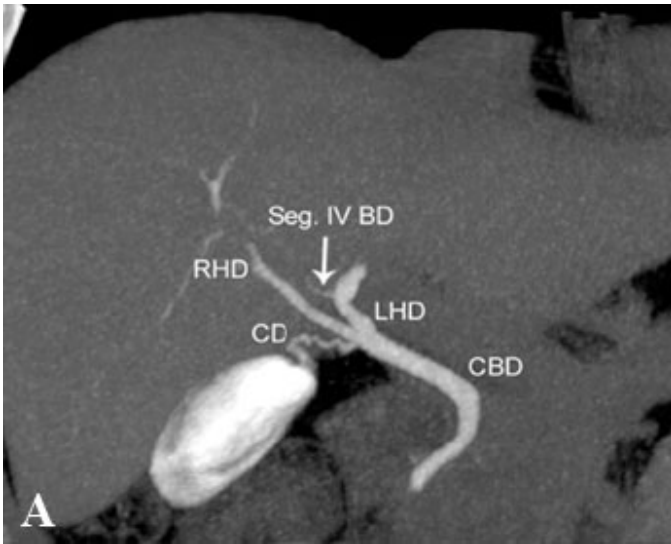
(A) Coronal MIP image from 3D multidetector CT cholangiography, performed after intravenous administration of iodipamide meglumine, shows the segment IV bile duct (Seg IV BD) draining into the left hepatic duct (LHD) in a 64-year-old man with a right lobe liver metastasis from colorectal cancer. (B) Mangafodipir-enhanced MIP image from preoperative MR cholangiography shows biliary trifurcation in a 52-year-old liver donor. CBD, common bile duct; CD, cystic duct; RHD, right hepatic duct; LHD, left hepatic duct; RAHD, right anterior hepatic duct; RPHD, right posterior hepatic duct.
